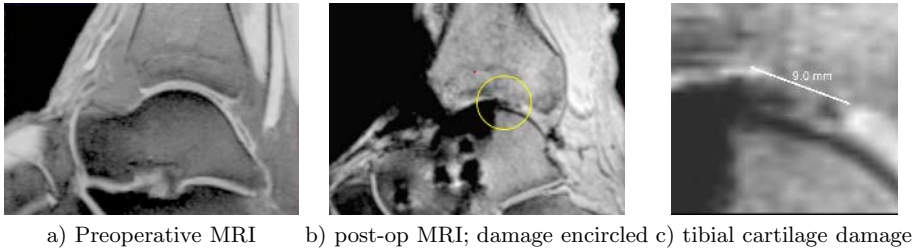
Medial view of the operative result in MRI
